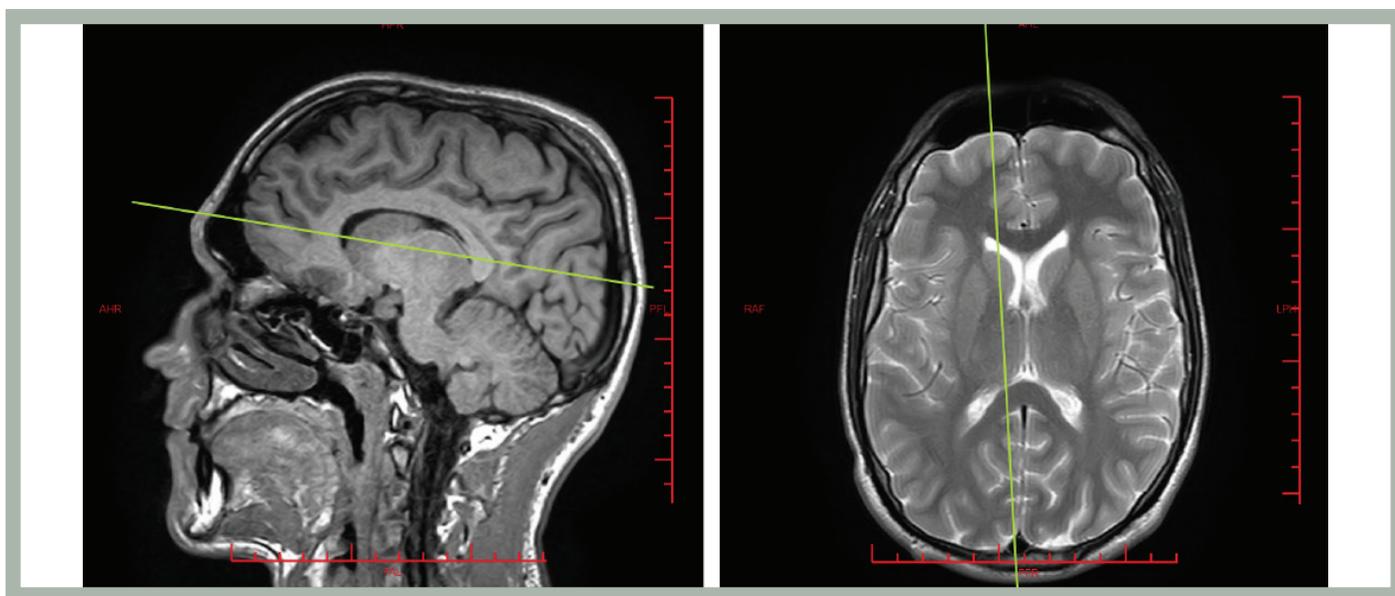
Cranial magnetic resonance imaging
